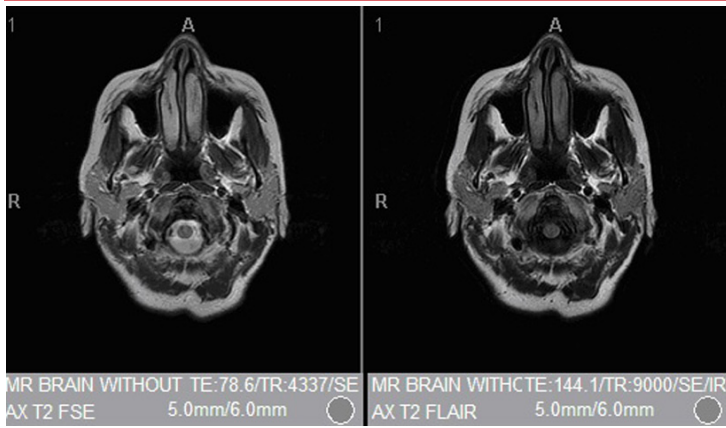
Magnetic resonance imaging (MRI) of the brain obtained post ablation
